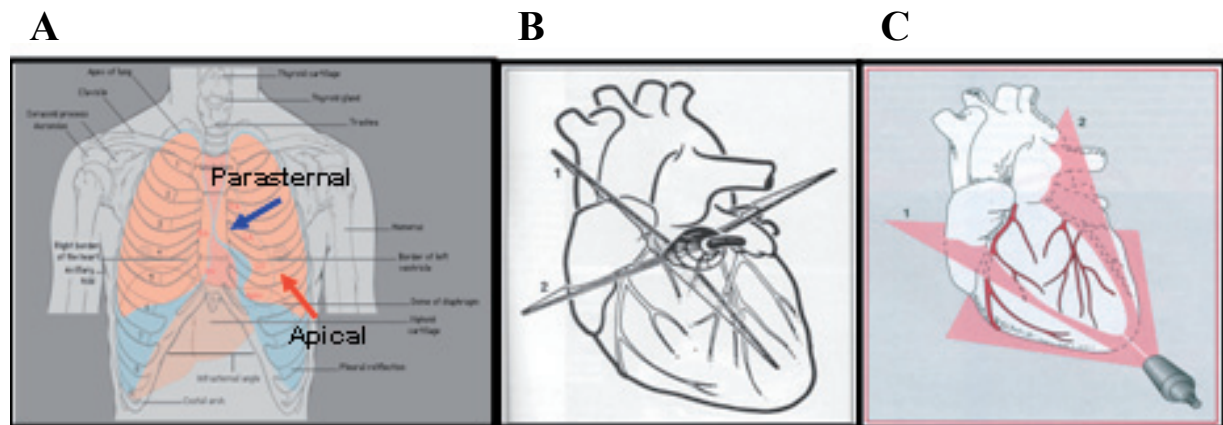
(A) The position of the transducer to obtain the parasternal and apical views. (B) In the parasternal long-axis window the transducer is placed next to the sternum (1) and then rotated 90° to obtain the short-axis view (2). (C) Apical views are achieved by placing the transducer apically and rotating the transducer 60° to obtain the each plane. Reprinted with permission [7]
